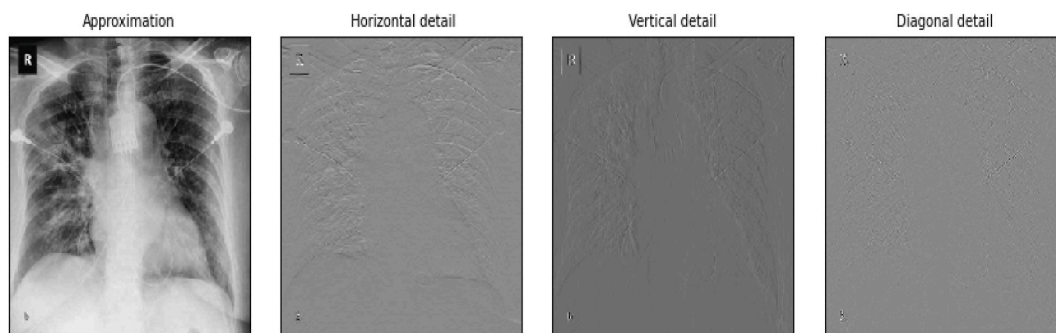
Wavelet transform technique on a sample Covid-19 chest X-ray image.
